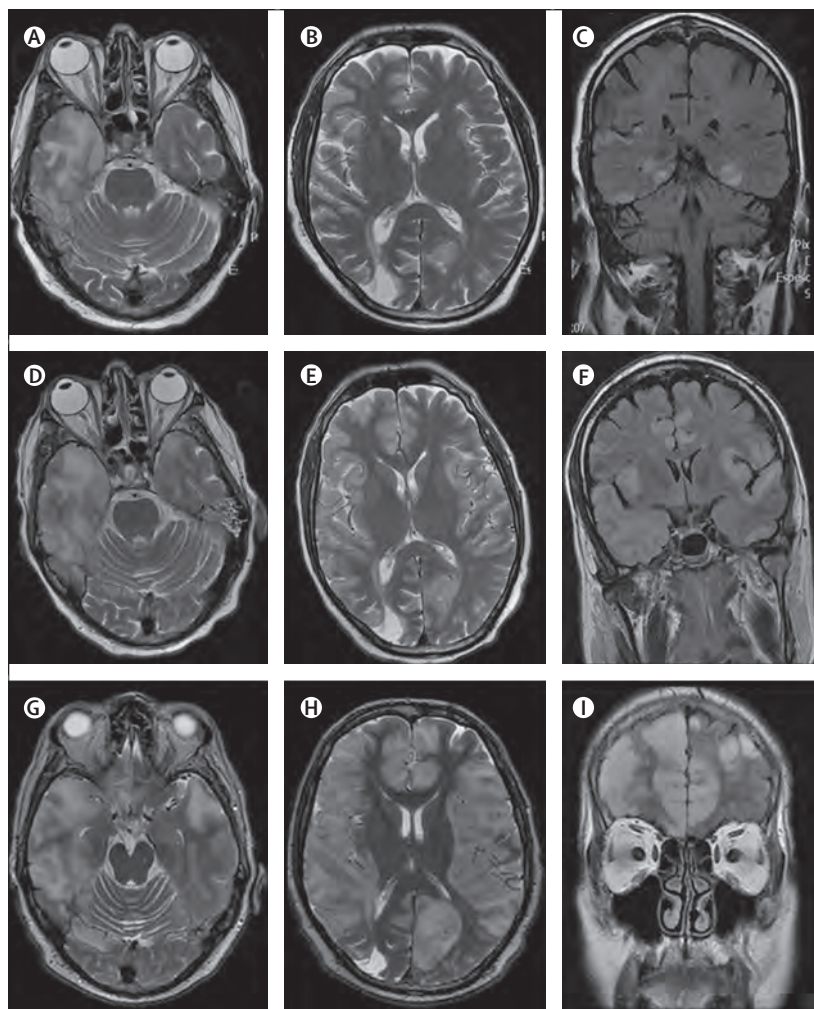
MRI findings in index patient 2
